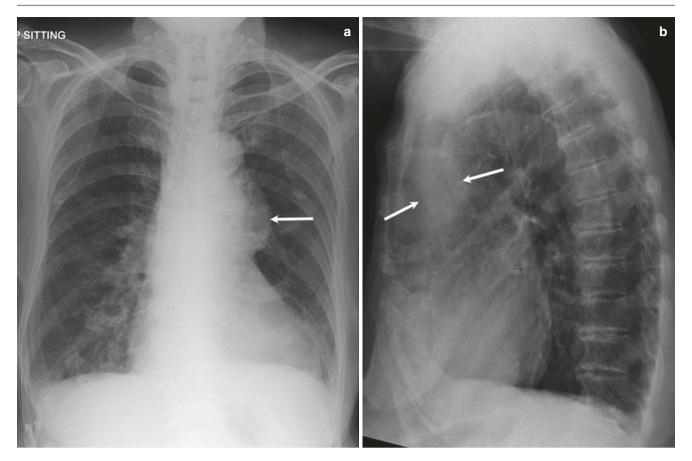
61-year-old man with anterior mediastinal thymoma. (a) Frontal radiograph shows an opacity in the midline, silhouetting the left heart border but not silhouetting the descending aorta. Hilar vessels can
